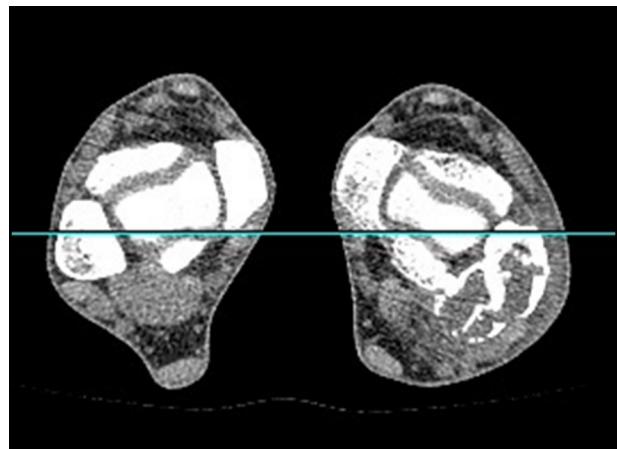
Helicoid computed tomography of the ankles bilaterally, one year after the surgery.
